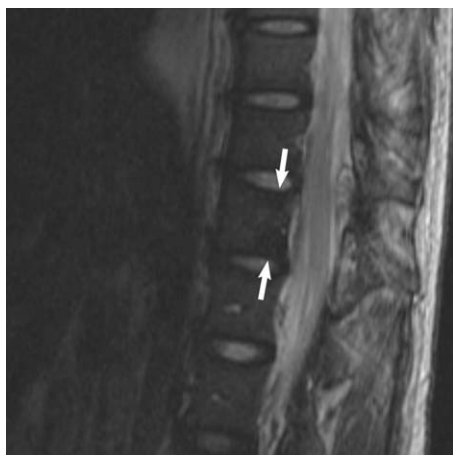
T2-weighted images (T2WIs) are frequently insensitive for detecting vertebral metastatic lesions because the lesions show similar signal intensity to marrow. The L1 metastasis is barely detectable (*arrows*) on this T2WI but quite visible on a T1-weighted image (see Fig. 7).
